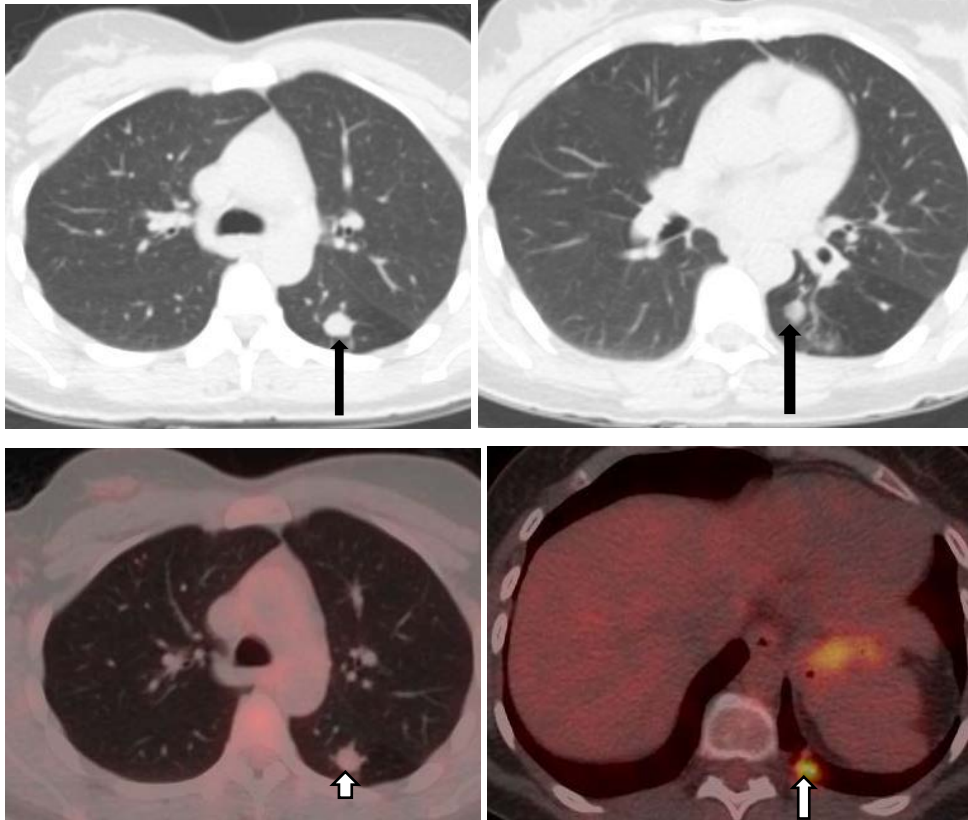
A 43-year-old with luminal disease with a left lung non-spiculated lesion suspicious on FDG PET/CT. Subjected to a CT-guided biopsy. SUV_{max} Primary breast 16.4 lung lesion 4.8 Biopsy results were negative for malignancy.
